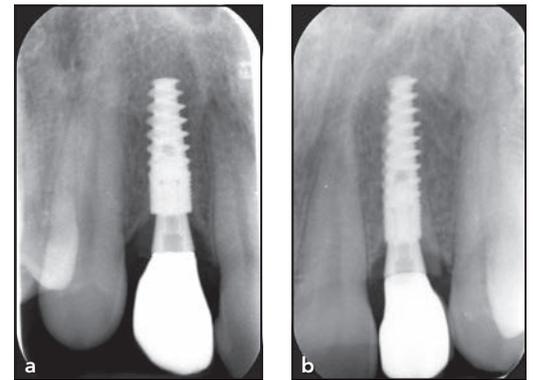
Posttreatment intraoral periapical radiographs of (a) tooth 12 and (b) tooth 22 at delivery of the definitive ceramic restorations.
